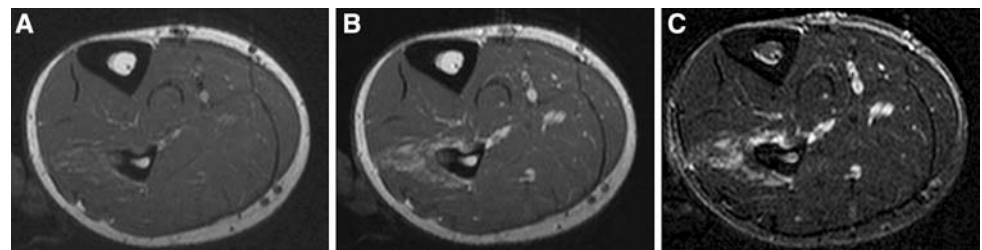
Postinterventional control in the open high-field MRI. Subtraction image (C) of T1-w TSE native (A) and contrast-enhanced T1-w TSE (B) was performed to confirm total ablation, typically showing loss of nidal contrast enhancement (C)
